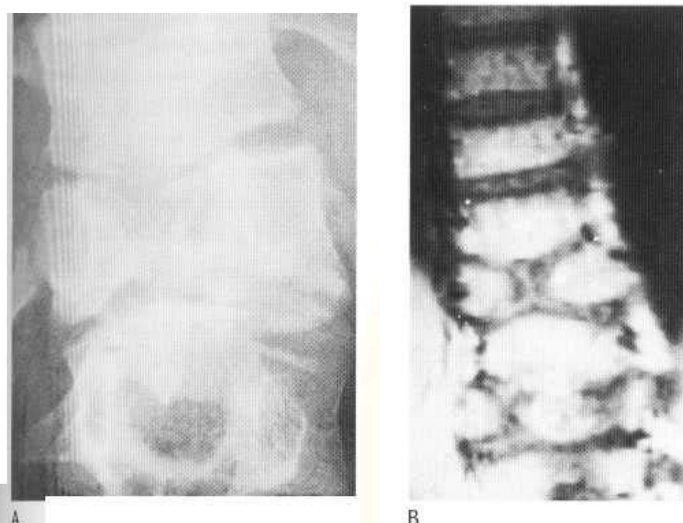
Butterfly vertebra. (A) The upper and lower surfaces of affected vertebra are V-shaped, and contiguous vertebrae are moulded into the deficient centre. (B) MR image showing the same deformity.
